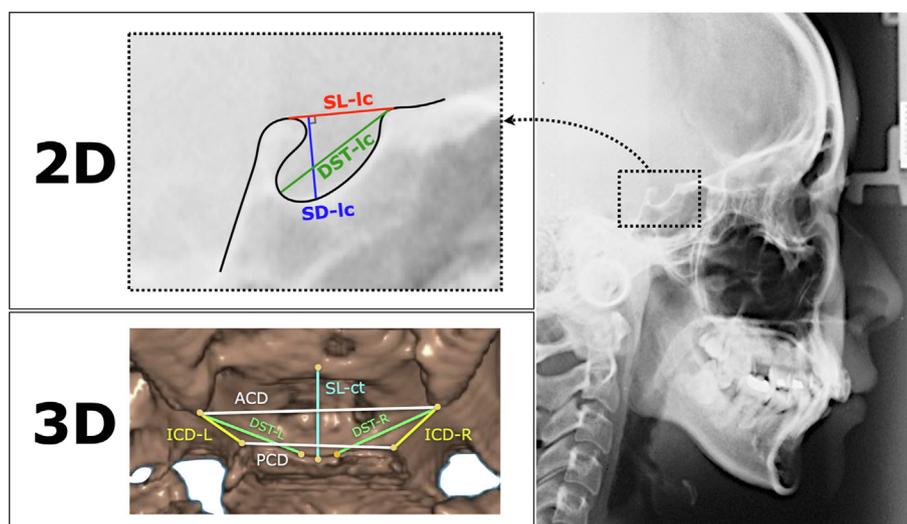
Comparison between 2D lateral cephalometric X-ray film and 3D CBCT for sella-turcica dimensions. SL-ic: sella length measured in lateral cephalogram; SD-ic: sella depth measured in lateral cephalogram; DST-ic: diameter of sella turcica measured in lateral cephalogram; SL-ct: sella length measured in CBCT; SD-ct: sella depth measured in CBCT; ICD-L: interclinoid distance-L; ICD-R: interclinoid distance-R; DST-L: diameter of sella turcica-L; DST-R: diameter of sella turcica-R; ACD: anterior clinoid distance; PCD: posterior clinoid distance.
